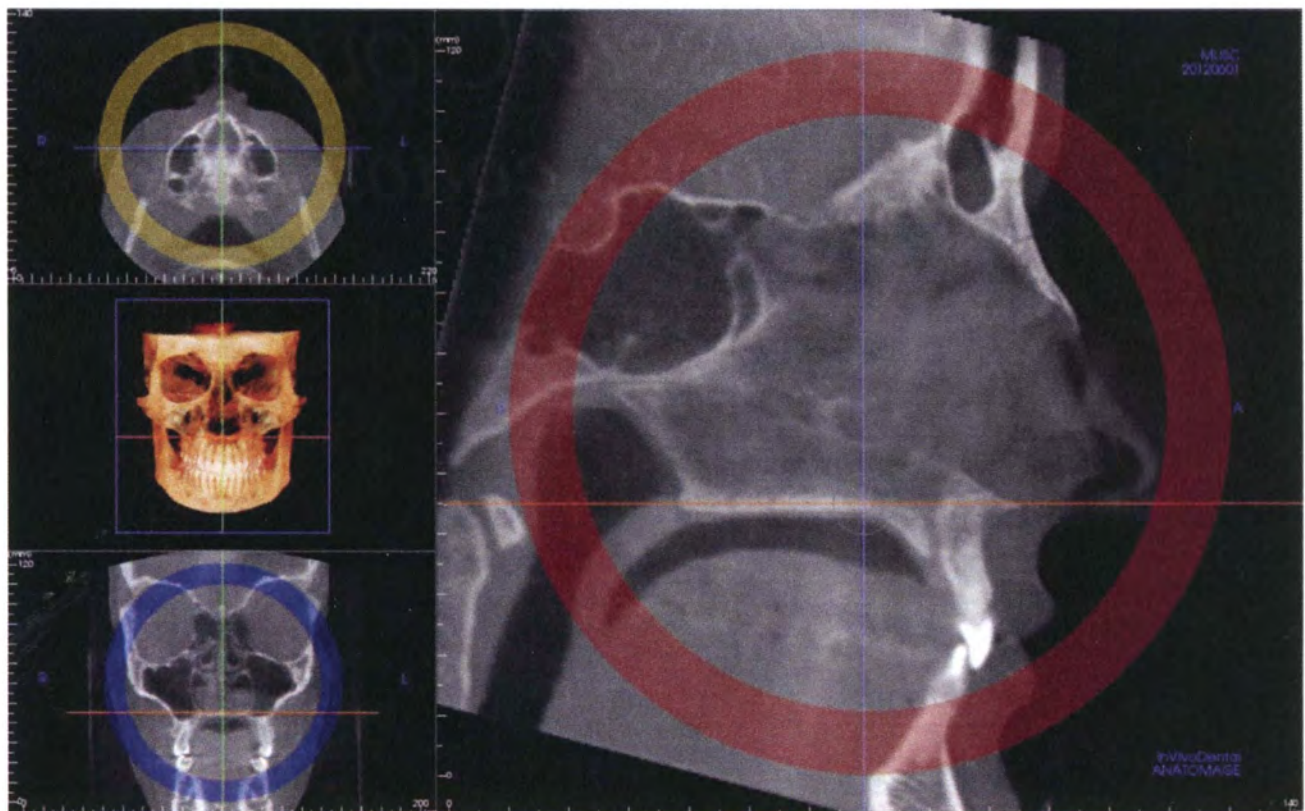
CBCT orientation of the palatal plane. This is the view utilized in step 2 of the orientation process for each CBCT evaluated orienting the palatal plane with a 0° line
